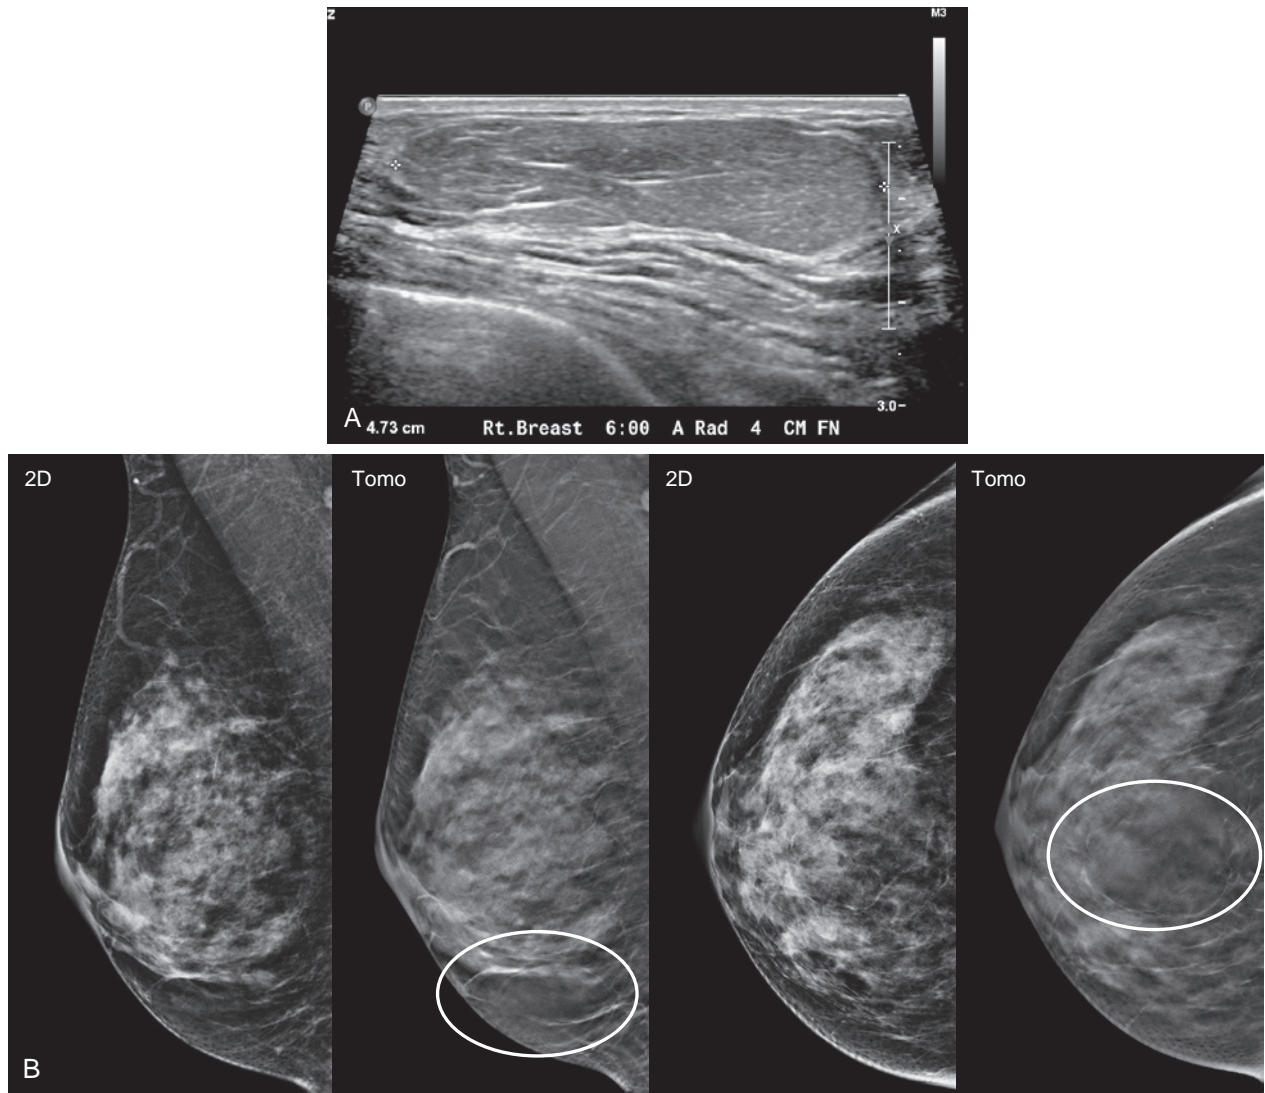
Lipoma. (A) A 58-year-old woman presents for screening breast ultrasound, which demonstrates a benign-appearing isoechoic mass in the right breast at the 6-o'clock position. (B) A corresponding fat-containing mass with a thin capsule (*circles*) is best seen on tomosynthesis images of her preceding screening mammogram, consistent with benign lipoma. BI-RADS 2.
